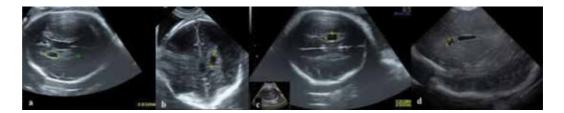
Benign, small dimensions, non-evolving intracerebral cyst: 28 WA (a and b), 30 WA (c), and postpartum, by means of transfontanellar ultrasound assessment (d).
